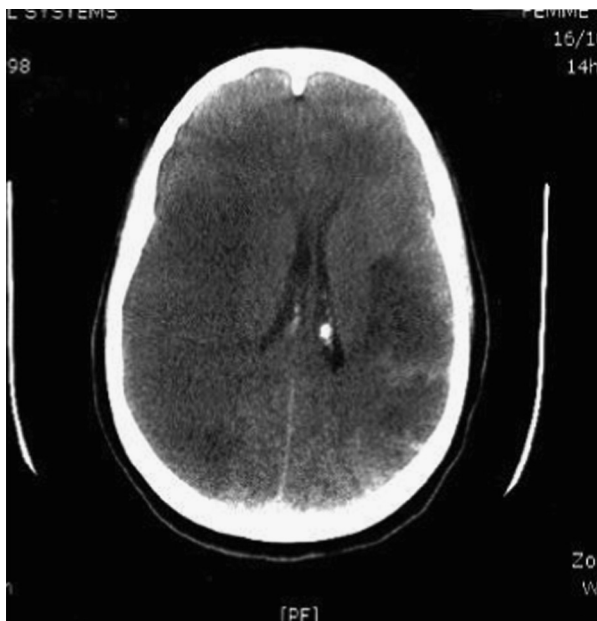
Computed tomographic scan of the brain of case 1 revealing an extensive infarction of the right cerebral hemisphere with important edema of the brain.
